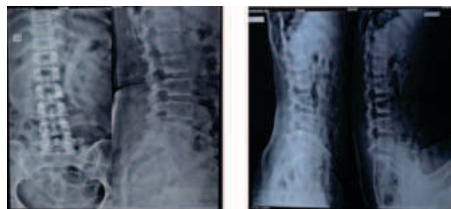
Pre-Op X-ray-AP and Lateral views
